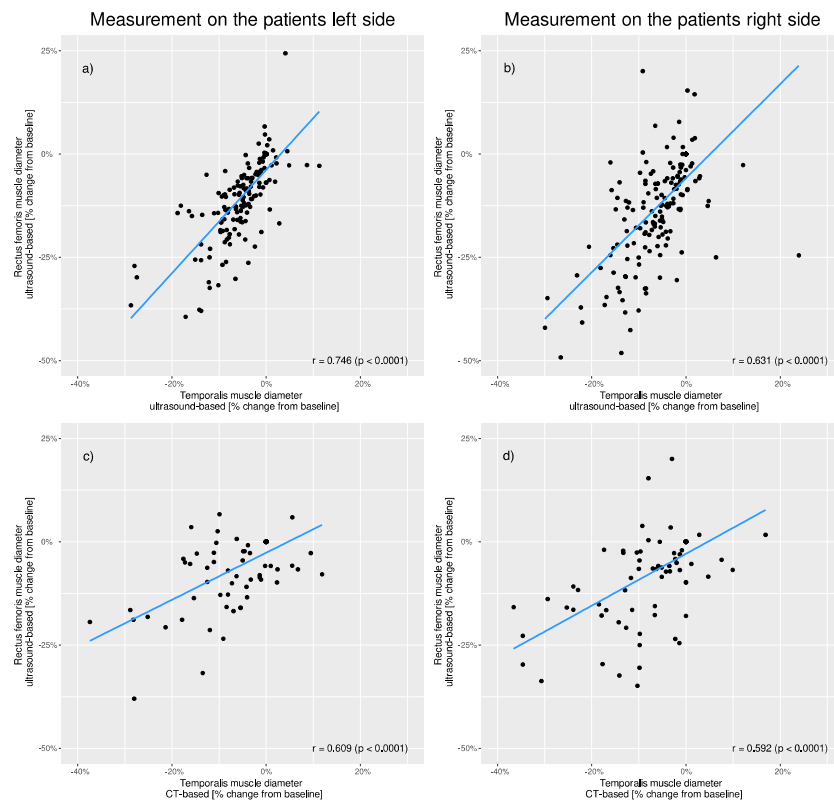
Correlation of percentage changes in muscle thickness between different muscle groups and different measurement techniques. Comparison of the patients' (a) left and (b) right-sided ultrasound-based rectus measurements to ultrasound-based temporalis measurements. Comparison of the patients' (c) left and (d) right-sided ultrasound-based rectus measurements to CT-based temporalis measurements.
